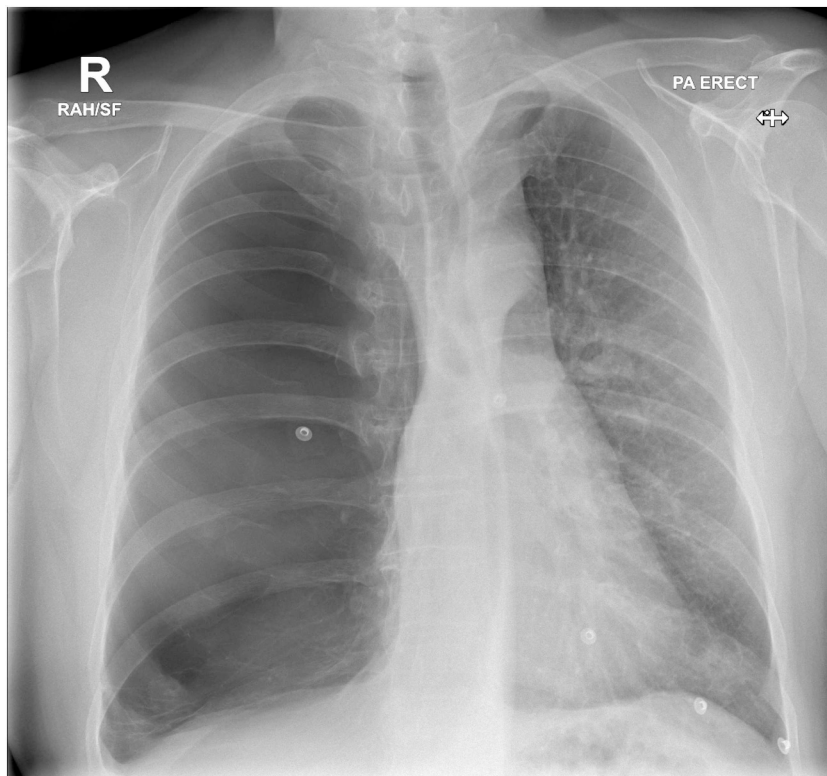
Chest radiograph in 2015 showing enlarging bulla.
